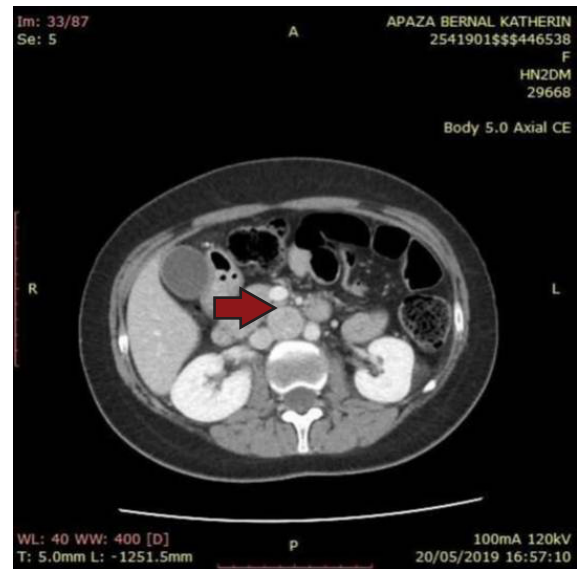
Abdominal CT scan showing a solid mass with defined borders located in the retroperitoneal intercaval region
